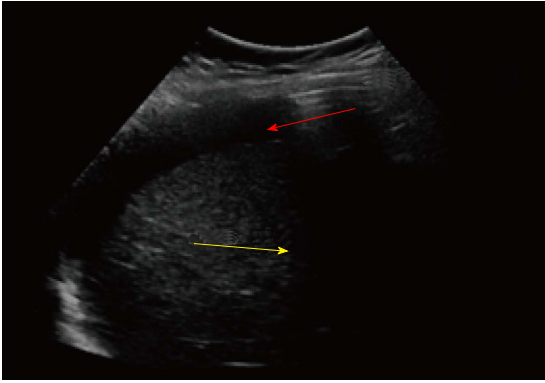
Abdominal ultrasound at epigastric level shows moderate amount of free fluid (yellow arrow) and reverberation artifact immediately under the abdominal wall compatible with intraperitoneal free air (red arrow).
